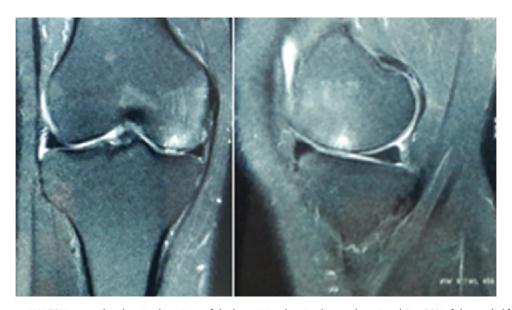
Pretreatment MRI T2W coronal and sagittal sections of the knee joint showing bone edema involving 70% of the medial femoral condyle along with a subchondral cyst, thinning of the articular cartilage, and contour alterations of the cartilage.
